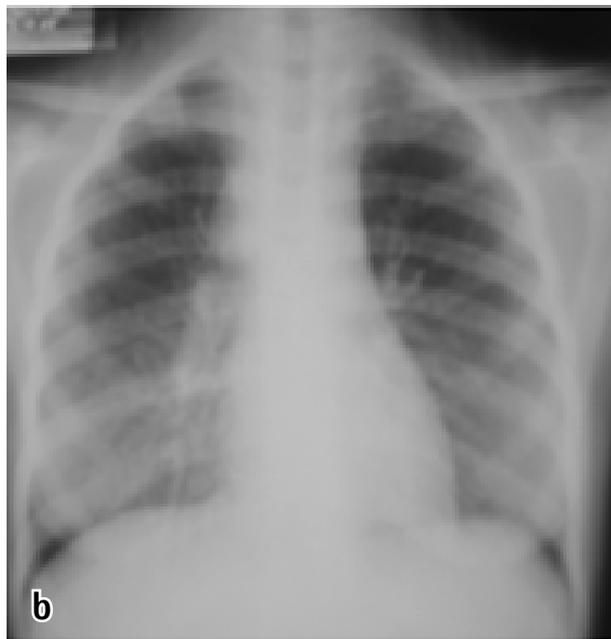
Drug-resistant TB presenting as paradoxical IRIS in a 12-year-old girl with pulmonary and abdominal TB and severe immune suppression (chest radiograph a). She was sputum smear positive and had a CD4 count of 31 cells/ μ l. Anti-TB therapy with four drugs was initiated and she responded well, smear conversion taking place within 3 weeks. ART was started 3 weeks after initiation of TB therapy, and 7 days later she developed a high fever, severe abdominal pain and food intolerance. The sputum smear was now positive, and a chest radiograph (b) suggested miliary TB. Steroids were added with some clinical improvement. Rifampicin resistance was confirmed after 48 days on TB therapy and 27 days on ART.
